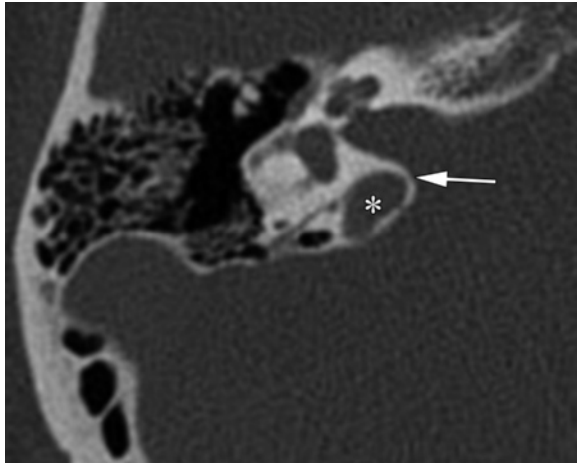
High-riding jugular bulb. Axial nonenhanced CT scan (bone algorithm) shows a high-riding jugular bulb (*) that lies directly adjacent to the posteroinferior wall of the IAC (arrow). A high-riding bulb complicates the drilling process and exposure, especially with a translabyrinthine approach. If necessary, the bulb can be compressed inferiorly, but not without risk of injury or thrombosis.
